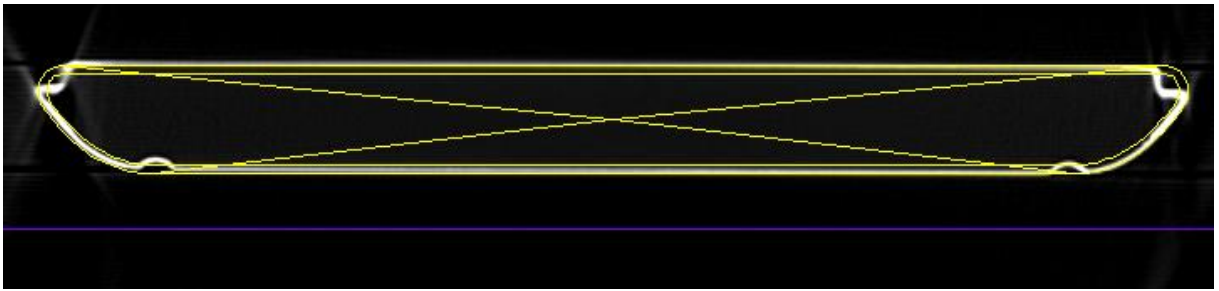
The couch model structures on the CT scan of the Varian IGRT couch on the level of the H4 notch
